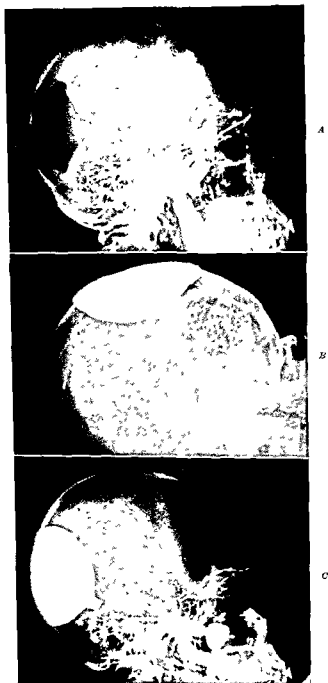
Appearance of skull by x-ray before and after plating A, Preplating defect; B, tangential view of plate in place note close approximation at plate edges C, lateral view of skull with plate in place
